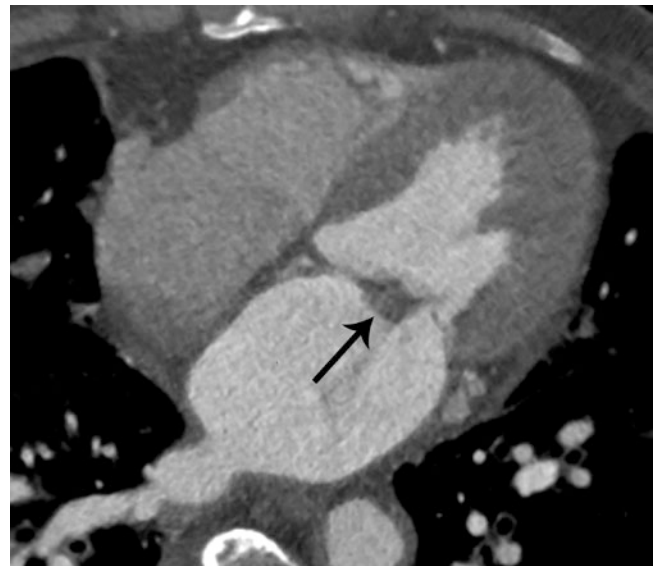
Image in a 55-year-old woman with stroke. Oblique sagittal reformat CT image shows a contrast jet from LA and RA (arrow) through the ASD. The direction of the jet is perpendicular to the interatrial septum. ASD atrial septal defect
